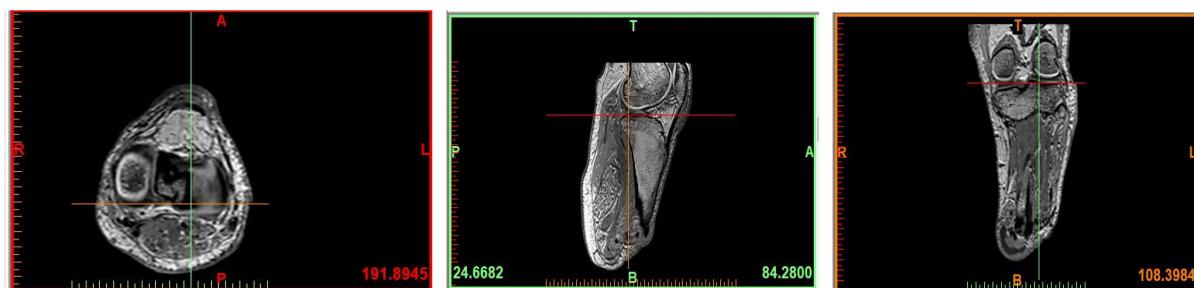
MRI images of the stump
